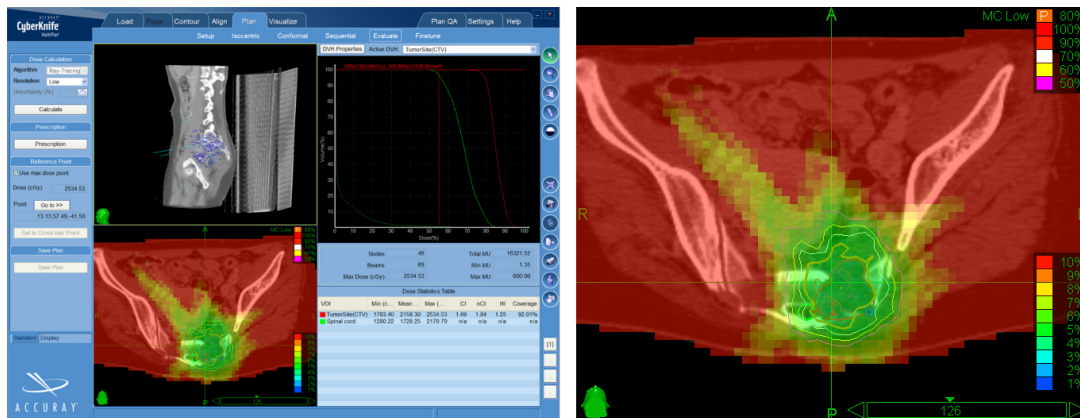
Plan evaluation for a spine case using the MultiPlan® software. Right half is a detail view of the bottom-left tab. (top-left tab) Sagittal view of the treatment beams. (top-right tab) Dose-volume histograms for different VOIs. (bottom-left tab) Dose colourwash and isodose curves overlaid onto axial CT slice. (bottom-right tab) View of numerical dose statistics. Source: Accuray [52].
